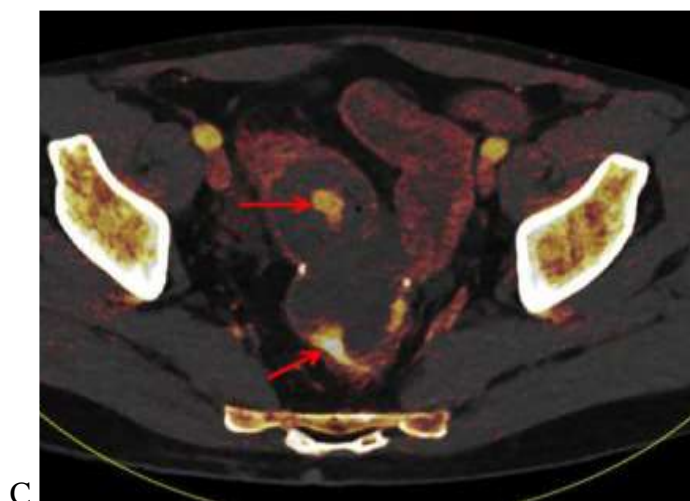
51-year-old male with prior colectomy for *Clostridium Difficile* colitis presenting with rectal bleeding. “Mixed” image from a dual energy CT scan in the portal venous phase (A) shows hyperattenuating material within the distal small bowel and rectum (red arrows). On the virtual non-contrast image (B), this material is not present within the bowel lumen, showing that this is not ingested material. The anastomotic suture material remains visible on the VNC image (yellow arrow). On iodine overlay image (C) with iodine content color-coded in orange, the hyperattenuating material within the bowel lumen demonstrates iodine content, further confirming that this represents active extravasation.
